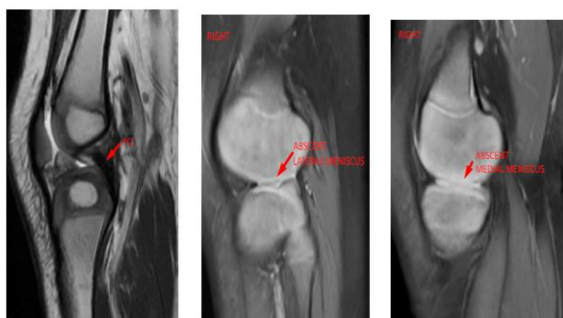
Right Knee MRI in Seq: T2wi / PDFS in Sagittal Plane Shows Secondary Signs of PCL Shows Hypoplastic Medial and Lateral Meniscus
